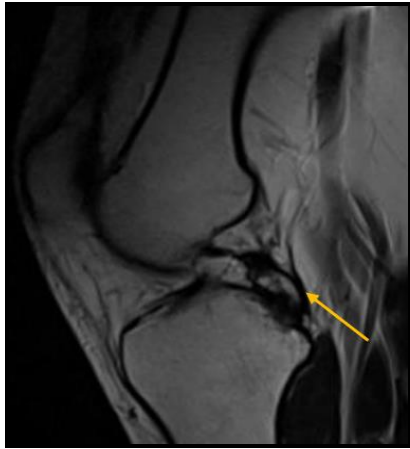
MRI Findings: the posterior cruciate ligament distal bony avulsion is noted attached to relatively small sized ligament (Yellow arrow), picture matching with chronic PCL bony avulsion.
